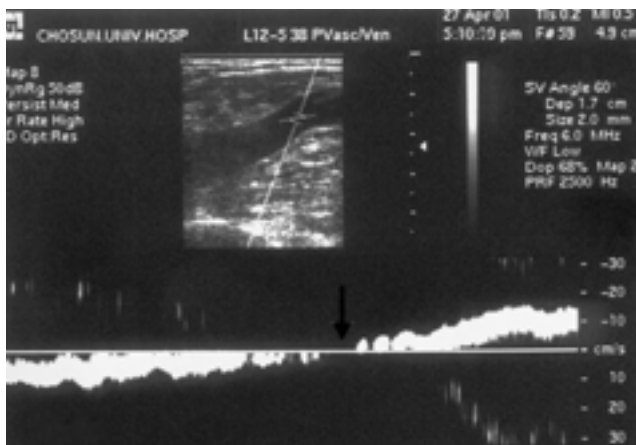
Greater saphenous vein reflux. Doppler spectrum shows flow reversal during the Valsalva maneuver.
